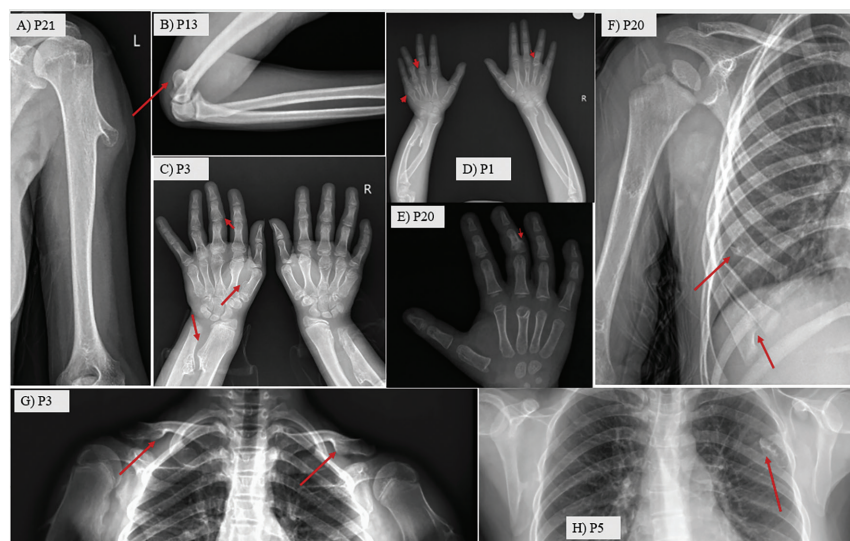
Representative examples of multiple exostoses/osteochondromas involving the upper extremities, clavicles, and ribs in patients with hereditary multiple exostoses. Red arrows indicate the lesions. A) P21: Exostosis of the proximal humerus. B) P13: Exostosis around the elbow (at the level of the proximal forearm). C) P3: Multiple exostoses of the hand and wrist, involving the metacarpals, phalanges, and distal forearm bones. D) P1: Multiple exostotic foci in both hands and the forearm, predominantly at the metacarpal/phalangeal level. E) P20: Exostosis at the level of the phalanx. F) P20: Rib-localized exostoses on the shoulder girdle and chest radiograph. G) P3: Bilateral clavicular exostoses on a shoulder girdle radiograph. H) P5: Exostosis in the scapular region on a shoulder girdle/chest radiograph
